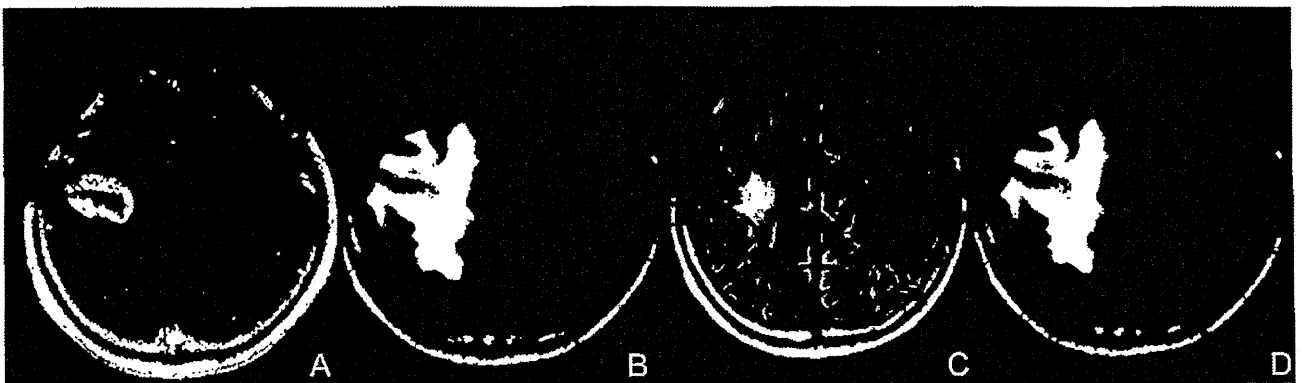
A representative case of radiation necrosis treated with bevacizumab. The original disease was a metastatic brain tumor from lung cancer. The metastasis was treated with SRS. One year after the SRS, marked enhancement (A) and perilesional edema (B) were recognized on magnetic resonance imaging (MRI). At the time of the MRI, the patient could not walk by himself. After three cycles of bevacizumab treatment 5 mg/kg biweekly, an MRI showed a marked decrease of the edema (C) and he could walk again. Unfortunately, 3 months after the bevacizumab treatment, MRI showed aggravation of the edema (D) with clinical symptom deterioration. Due to financial problems, the patient could not undergo a re-challenge of bevacizumab treatment. A: Gd-enhanced T<sub>1</sub>-weighted image. B–D: Fluid-attenuated inversion recovery images. SRS: stereotactic radiosurgery.
